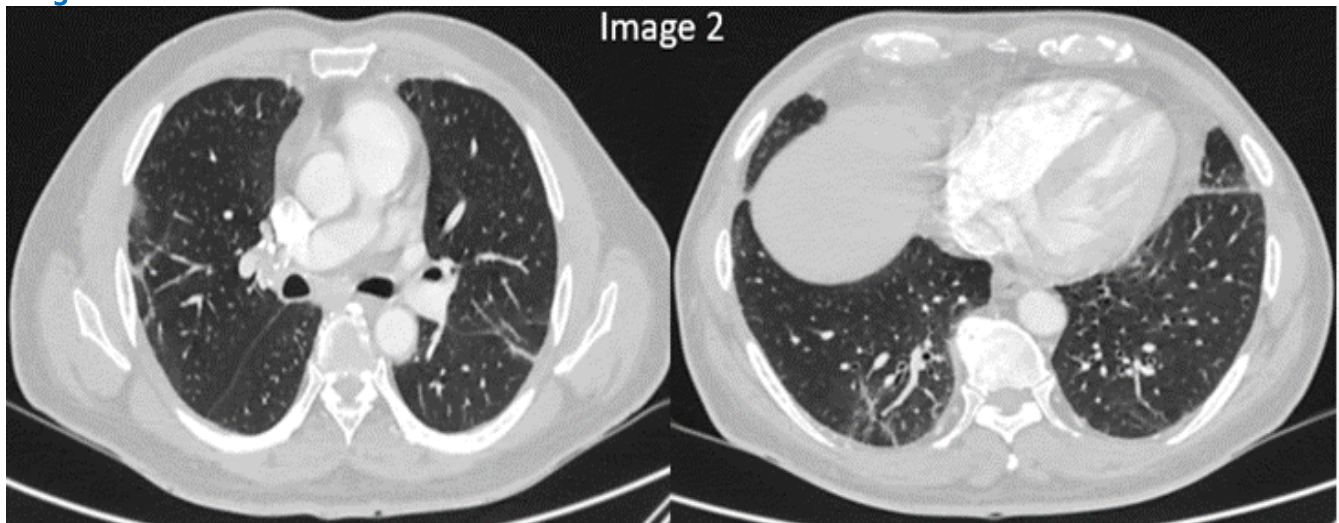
Chest CT in lung window. Axial cuts at different levels. August 2022. Almost complete resolution of the findings is observed, with some residual cylindrical bronchiectasis in the medial segment of the right lower lobe.
